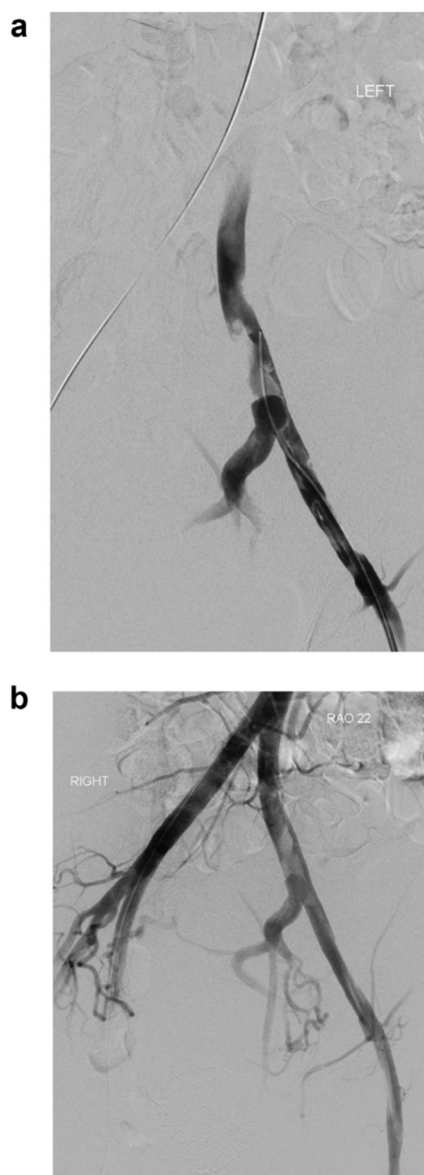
A Complication of prophylactic occlusion balloon placement. Thrombus is in the left common and external iliac arteries as filling defects. Patient still asymptomatic with warm, well-perfused leg throughout. b. Post thrombus aspiration. Some residual thrombus still; however, significant amount of the thrombus was aspirated and removed through the left common femoral artery sheath using a valveless sheath and guide catheter. Run off vessels all intact. Leg monitored and duplex ultrasound subsequently confirmed resolution of thrombus. No adverse sequelae.
